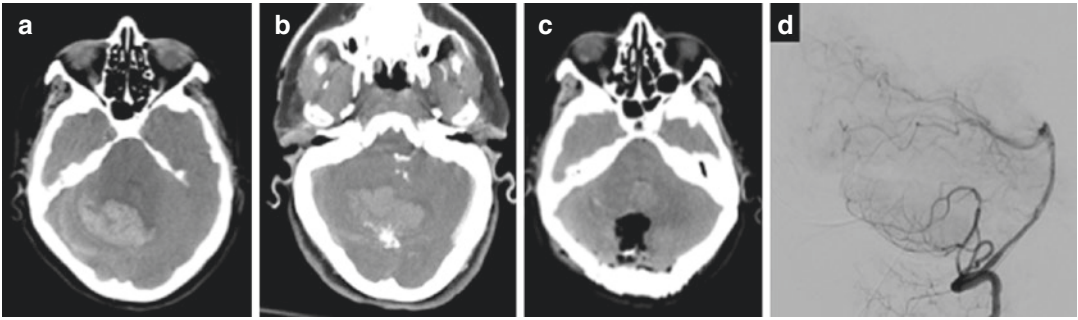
A 73-year-old woman presented with acute decline in mental status. (a) Non-contrast CT showed a cerebellar intraparenchymal hemorrhage. (b) CT angiography showed a superficial SM I AVM. (c) A suboccipital
